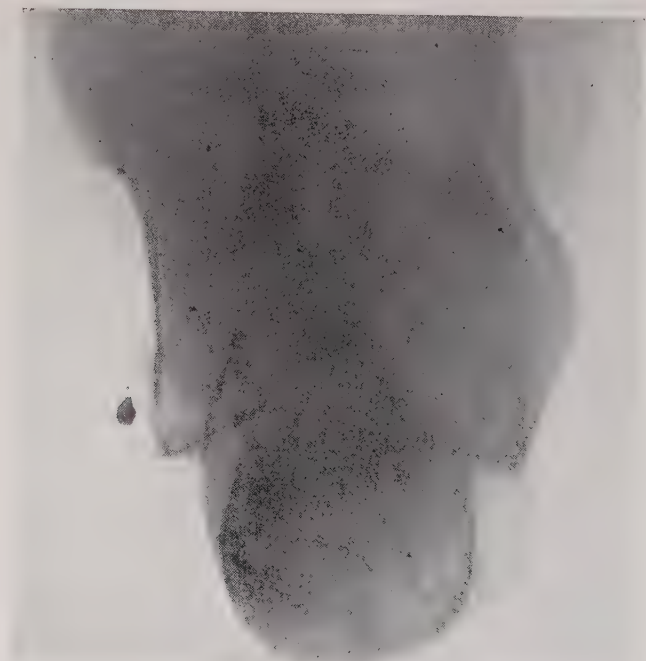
Fracture of the os calcis. The roentgenogram was made by directing the rays vertically downward through the heel. Note that the posterior fragment is displaced outward to the right. (Fracture Service, M. G. H.)
